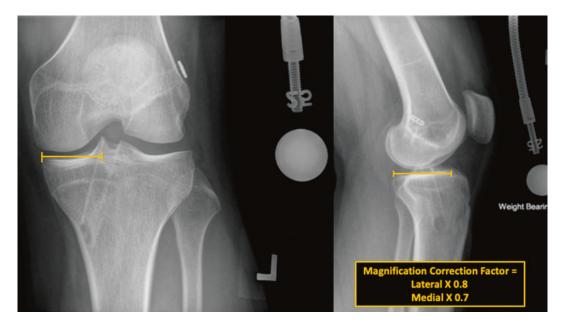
The Pollard method for measuring meniscal size. Meniscal width is measured on an anteroposterior X-ray from the tibial eminence to the periphery of the tibial plateau, and meniscal length is measured on a
